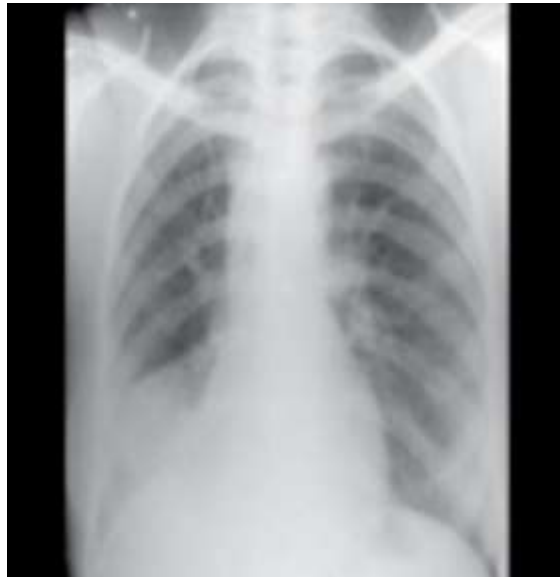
Chest X-Ray PA view showing clearing of shadows after anti-tubercular drugs.
